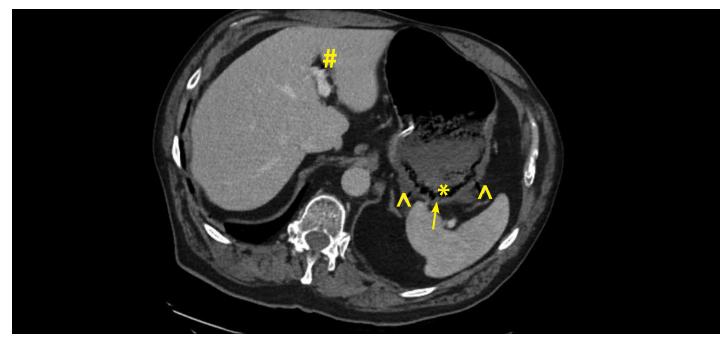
from the article "Successful nonoperative management of gastric ischemia and portal venous gas secondary to Sarcina ventriculi infection." Initial CT scan on postadmission day 1 showing the presence of intramural gas (denoted by *), portal venous gas (denoted by #), hypoenhancing posterior stomach body (denoted by yellow arrow), and gas in vasculature of stomach (denoted by ^). Article begins on page 354.
